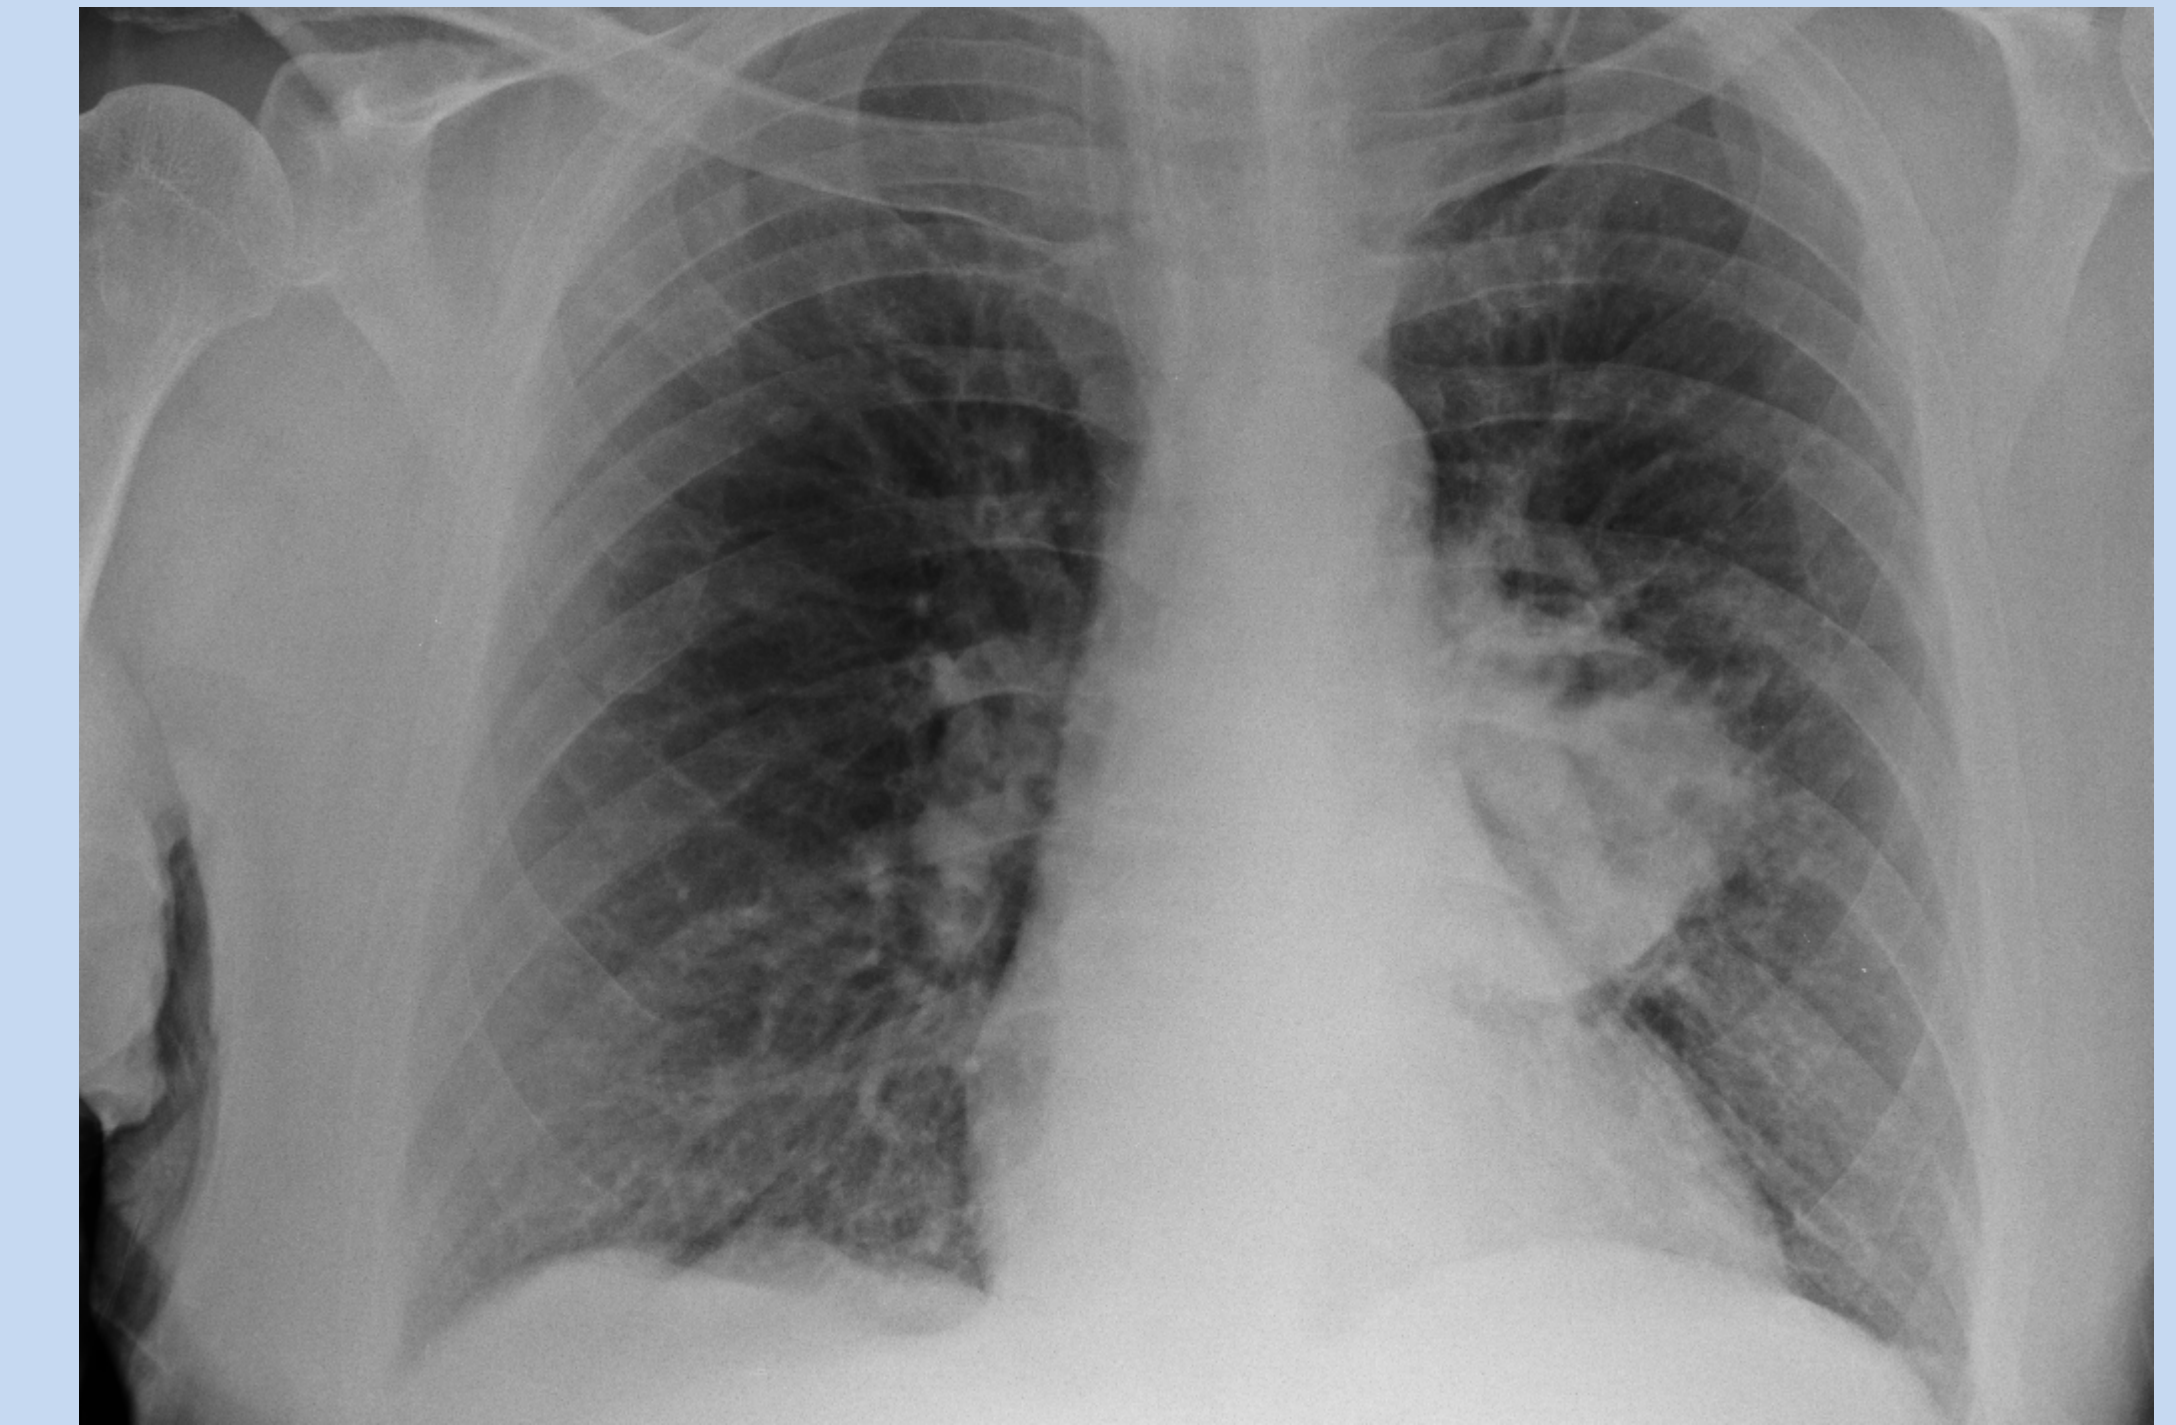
Patient chest x-ray showing left hilar mass 7cm in diameter
